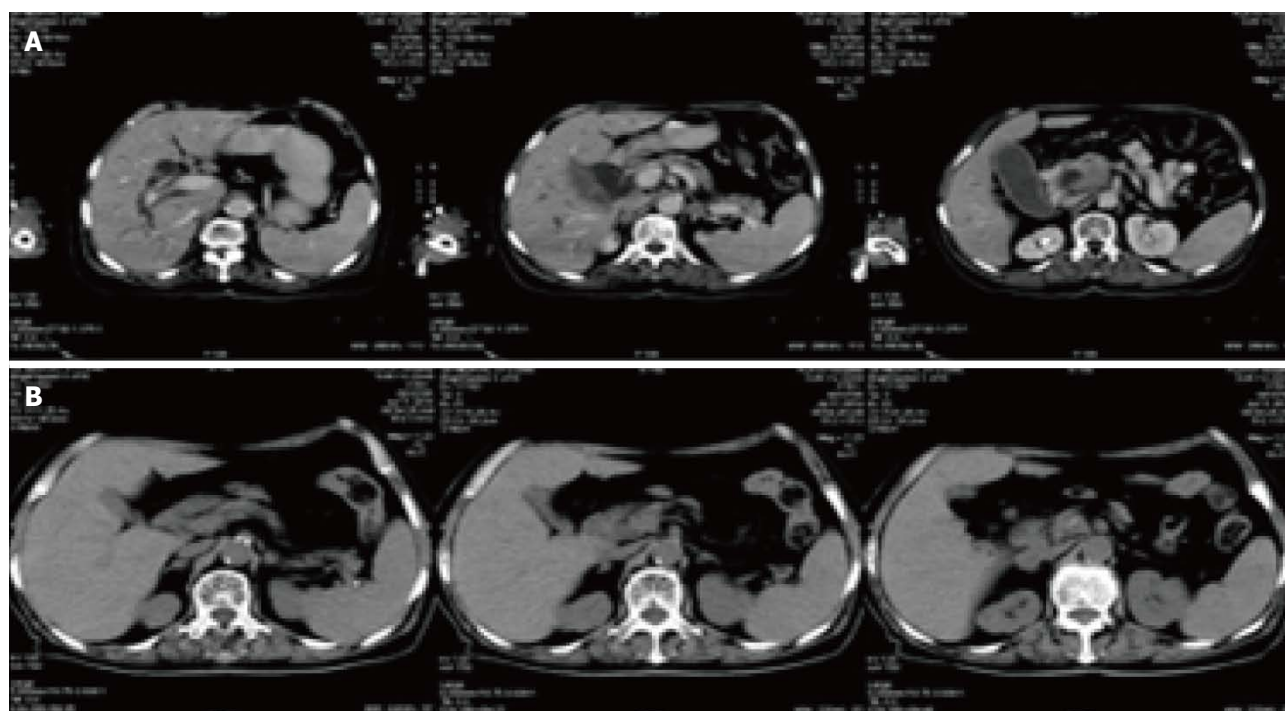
Changes of computed tomography slice before and after treatment in pancreatic cancer patients. A: Pancreatic head tumor mass (4.4 cm × 3.6 cm × 5.3 cm) accompanied by dilation of intrahepatic and extrahepatic bile duct, pancreatic duct and gallbladder before treatment; B: Most of the pancreatic head mass disappeared in 2 mo after B treatment. Low obstruction disappeared.
